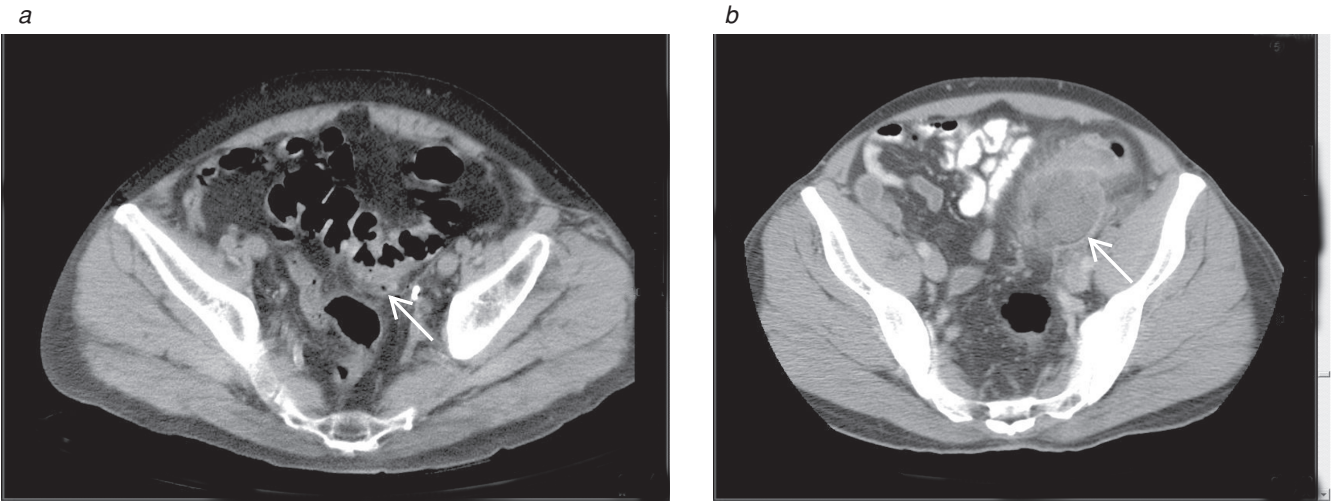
(a) A pelvic computed tomographic (CT) scan of an elderly patient with left lower quadrant abdominal pain of 2 days’ duration showing diverticulitis with a small amount of extraluminal air (white arrow). The patient was treated acutely with resuscitation and antibiotics alone and was discharged home without complications. (b) A pelvic CT scan of a middle-aged patient with a 1-week history of constipation and moderate pelvic pain showing left lower quadrant fluid collection consistent with peridiverticular abscess (white arrow). Proximal bowel is seen anterior to the abscess, distal bowel posterior. A percutaneous drain was placed, and elective colectomy with primary reanastomosis was performed 12 days later.
